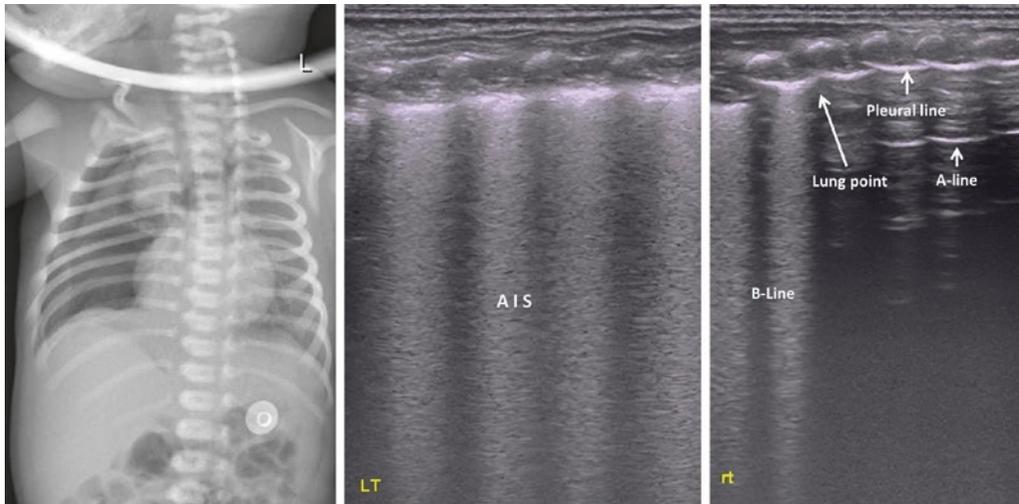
Ultrasonic manifestation of mild-moderate pneumothorax in a transient tachypnea of the newborn (TTN) patient. The gestational age (GA) and birth weight of this baby, who was admitted to our NICU because of breathing difficulties for 4 h with a diagnosis of TTN, were 38 weeks and 2550 g, respectively. The lung ultrasound showed an abnormal pleural line, adenocarcinoma
